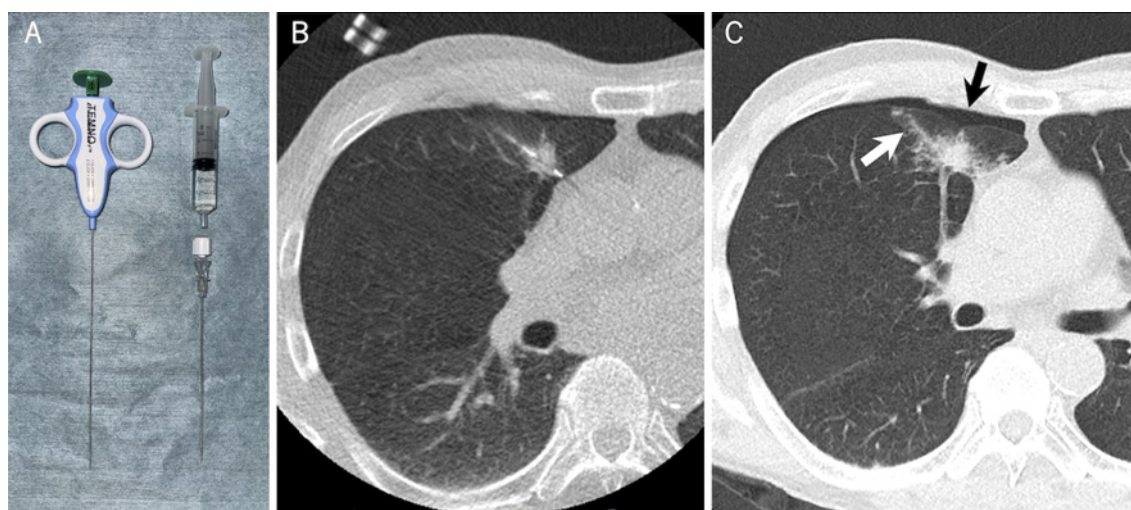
Instruments and representative images for CT-guided lung biopsy using saline tract sealing. (A) Instruments used for the procedure: a 19-gauge introducer needle, a 20-gauge biopsy needle, and a 5-mL syringe filled with normal saline. (B) CT image showing coaxial biopsy of a 2-cm lung nodule in the right upper lobe. (C) Post-procedural CT image demonstrating the saline-sealed needle tract as ground-glass opacity (white arrow) and a small pneumothorax (black arrow).
